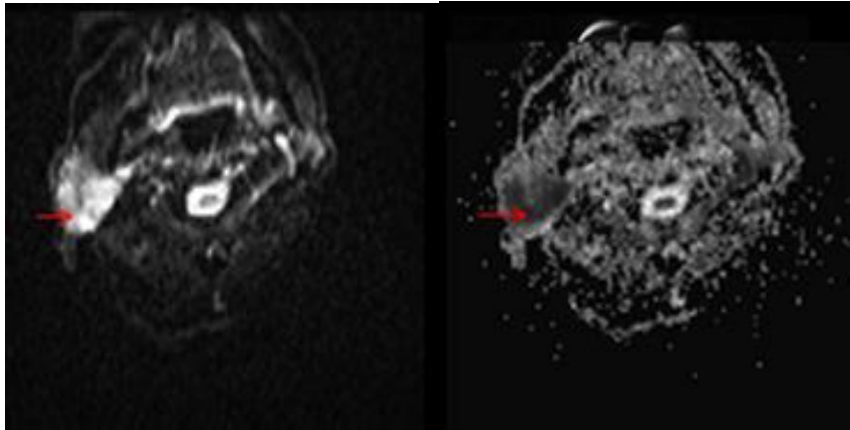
On DWI and ADC Mapping Sequences of the Lesion in the Right Parotid Gland shows Restricted Diffusivity Suggesting its High Cellularity. [Primary Nodal Non-Hodgkin's Lymphoma]
